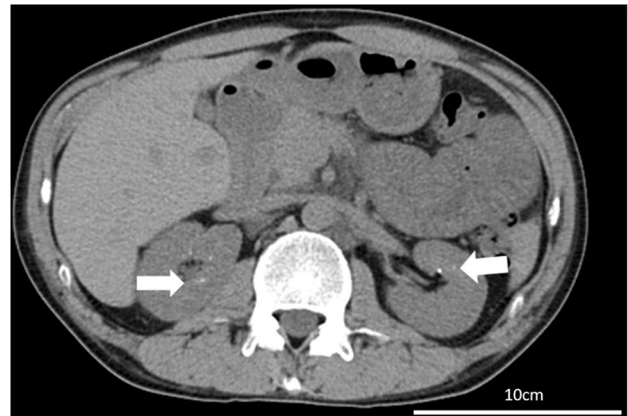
CT image of the abdomen. CT scan showed renal calcification (arrow), which was consistent with medullary calcification due to Dent’s disease. It also showed that small amounts of ascites, edematous wall thickening in the small intestine, and subcutaneous edema
